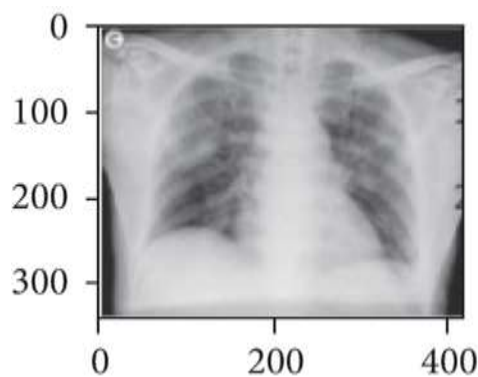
X-ray for Training:
